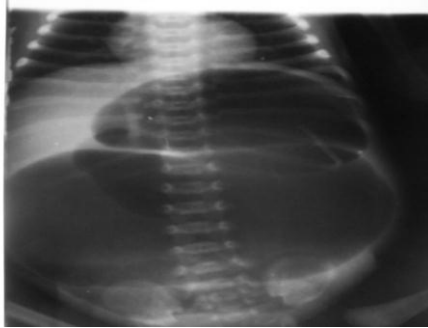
Supine abdominal radiograph of a 10 day old female who presented with proximal jejunal
